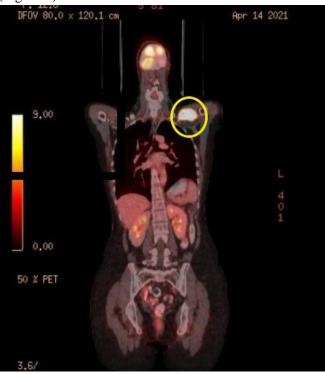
Positron emission tomography (PET)/CT of the whole body demonstrating an ill-defined lytic lesion with extensive soft tissue component seen in superior aspect of the left scapula with increased FDG uptake (SUV max 15.9) and multiple liver metastasis (Figure 2).
